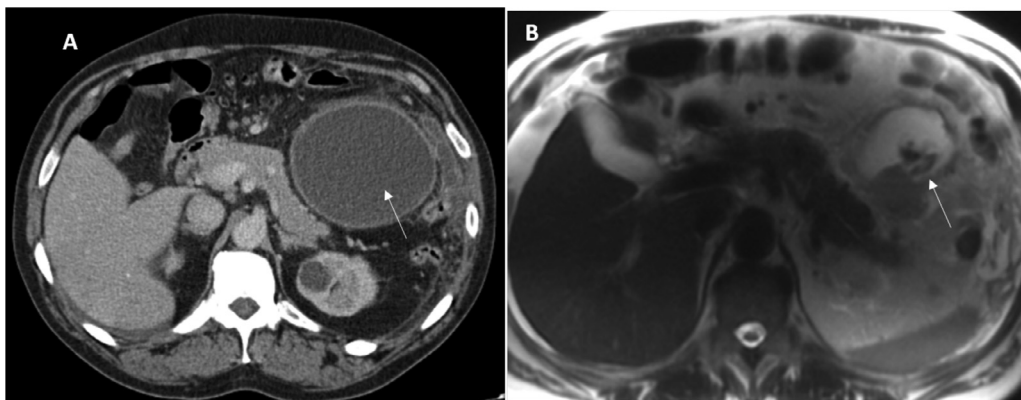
A 65-year-old patient with a history of 7 days of abdominal pain and elevated serum lipase. CECT (A) demonstrates a peripancreatic collection (arrow), and (B) T2-weighted MRI confirms heterogeneous material (debris) within this collection consistent with an acute extrapancreatic necrotic collection (ANC). No necrosis of the pancreas is present.
